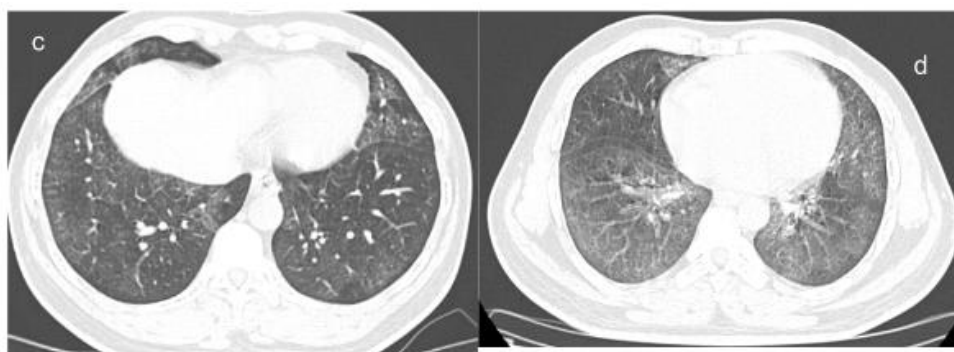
Follow up HRCT with significant clearing of (c) lower lobe (d) right middle lobe and Lingula
